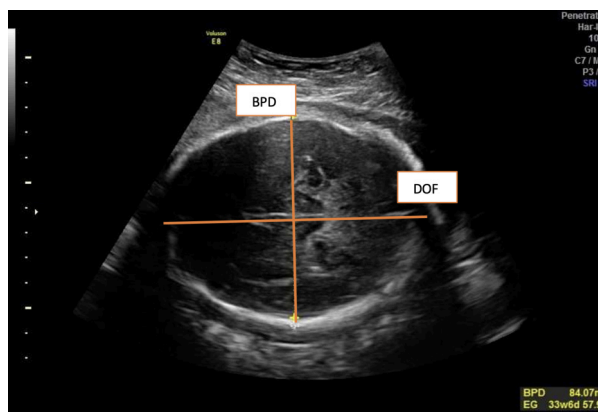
BPD and OFD measurements by ultrasound (78)
